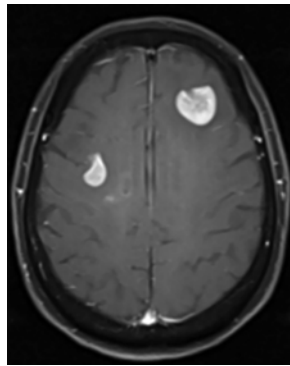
Brain MRI of further progressed primary central nervous system lymphoma. Brain MRI showed further progression on post-contrast T1 image after 2 cycles of (8 weeks) rechallenging biweekly high dose-methotrexate (HD-MTX), at 22 months since diagnosis.
